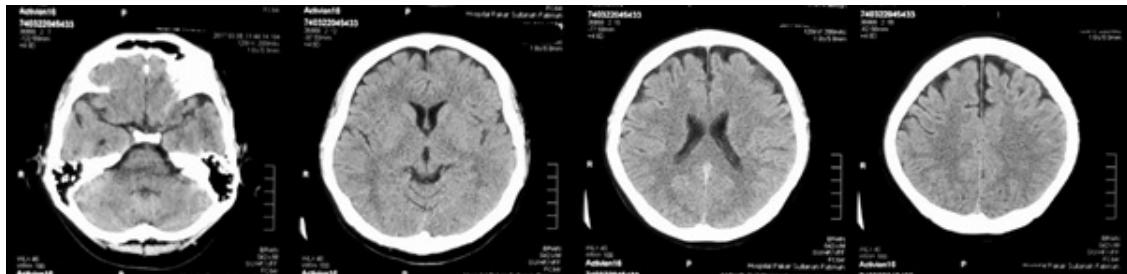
CT of the brain of a 43-year-old male with Lance-Adams syndrome.
